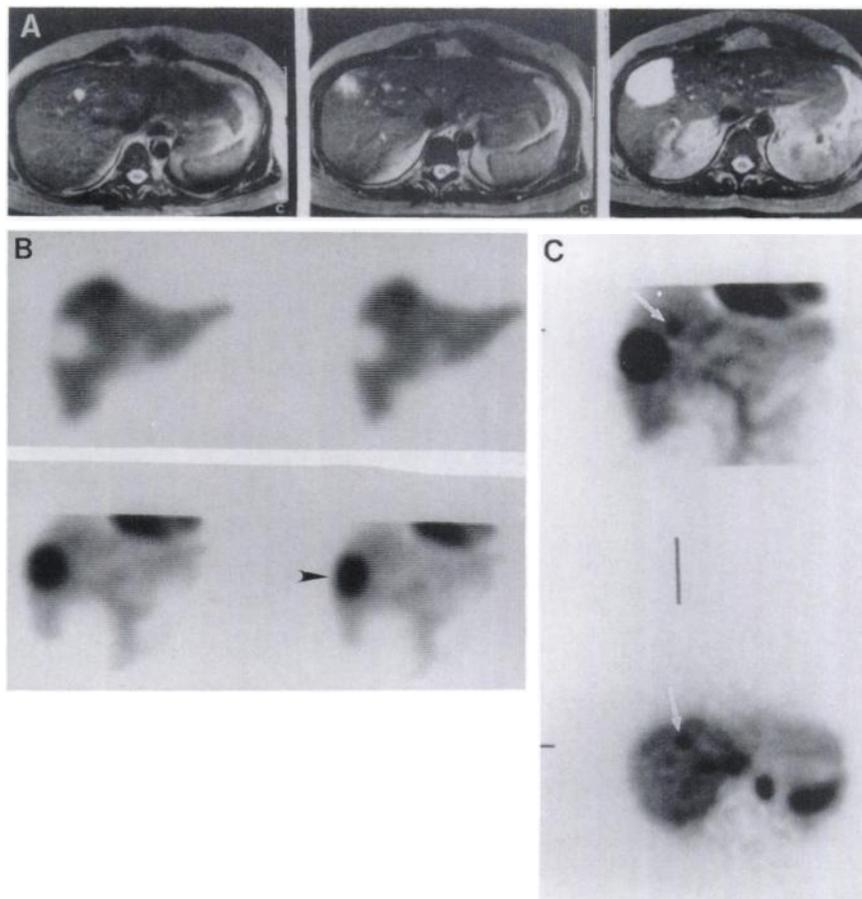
(A) T2-weighted MR image. Three selected sequential transaxial slices showing two lesions adjacent to each other, one large (6.5 cm) in the right slice and one small (0.9 cm) in the left slice. The middle slice has partial volume images of both lesions, but shows their close proximity. (B) Single-headed conventional SPECT showing two coronal slices: (above) the patient's ^{99m}Tc-SC liver spleen scan and (below) comparable ^{99m}Tc-RBC slices. The large lesion is clearly seen as hemangioma-positive on the Tc-RBC study (arrowhead), however, the smaller lesion was not seen. (C) Triple-headed SPECT. The coronal (above) and transaxial (below) slices clearly resolve the small 0.9 cm hemangioma (arrows) not seen in B with the single-headed SPECT camera. The other "hot" regions in the transverse slice are, from left to right, the portal vein, inferior vena cava, aorta, and spleen.
